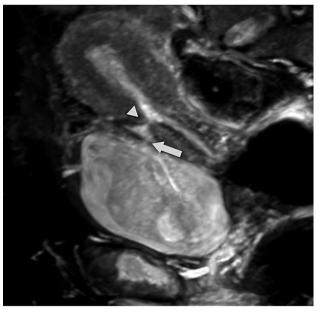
Sagittal T2 weighted MRI of the pelvis showing a tiny residual vesicouterine fistula. The persistant cesarean section scar defect (arrowhead), connects the endometrial cavity to the fluid collection seen between the uterus and bladder. The fluid collection is also connected through a tiny residual one-mm fistulous tract (arrow), to the trigone of the urinary bladder that appears tethered posteriorly at that region.
